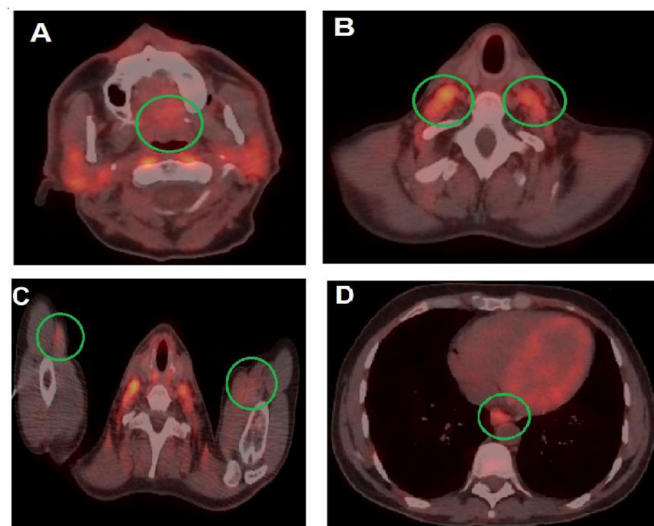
Positron emission tomography-CT. A disseminated disease across the lymphatic system: (A) base of the tongue, (B) cervical lymph nodes, (C) axilla and (D) mediastinum.
